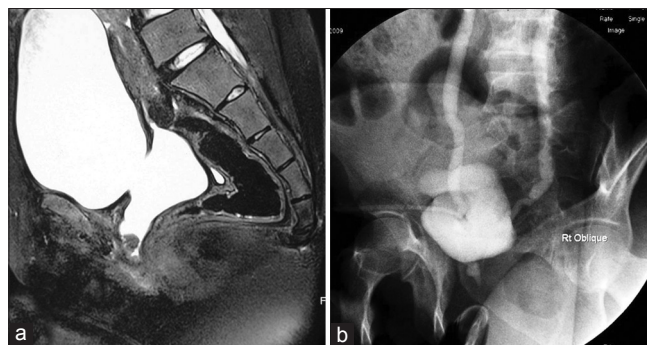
(a) Patient E: MRI (preoperative)—large trigonal fistula extending till bladder neck with moderate capacity bladder (b) Patient B: VCUG (after fistula repair)—bilateral reflux with partially open bladder neck and non-relaxing external sphincter
